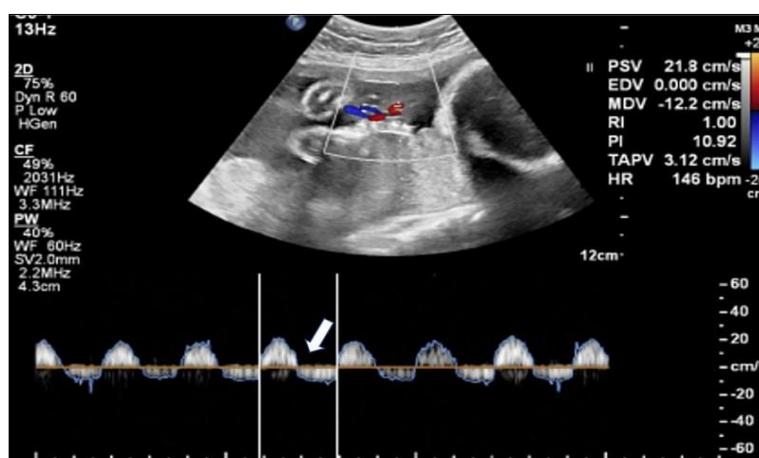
Doppler Ultrasound of Fetal Heart: Hemodynamic Assessment
